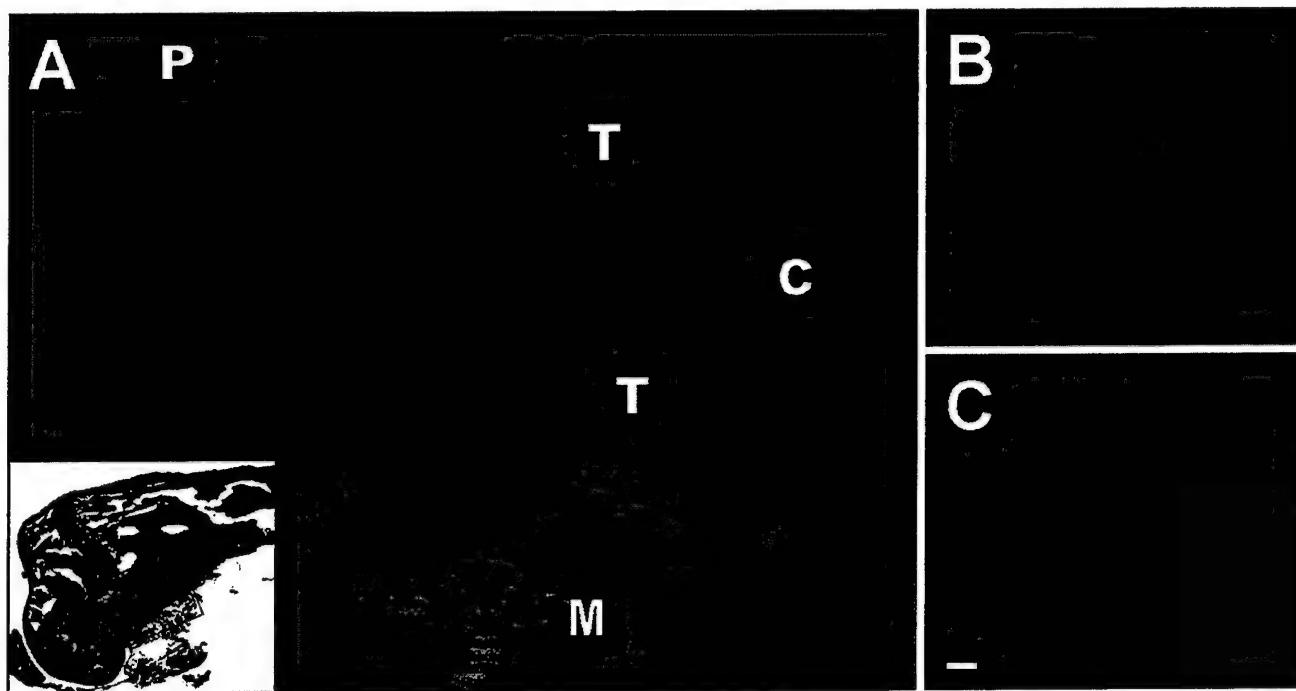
435^{GFP} skeletal metastases are osteolytic. A. A metastasis is shown in distal femur four weeks following intracardiac injection. Tumor within the medullary cavity has invaded through the cortical bone to the exterior of the shaft. Cortical bone (C), tumor (T), distal epiphyseal growth plate (P), skeletal muscle (M). B. X-ray (19 kVp) 7.5 weeks following i.c. injection shows significant osteolysis in proximal tibia corresponding to a fluorescing lesion (Figure C). Bar = 1 mm.
